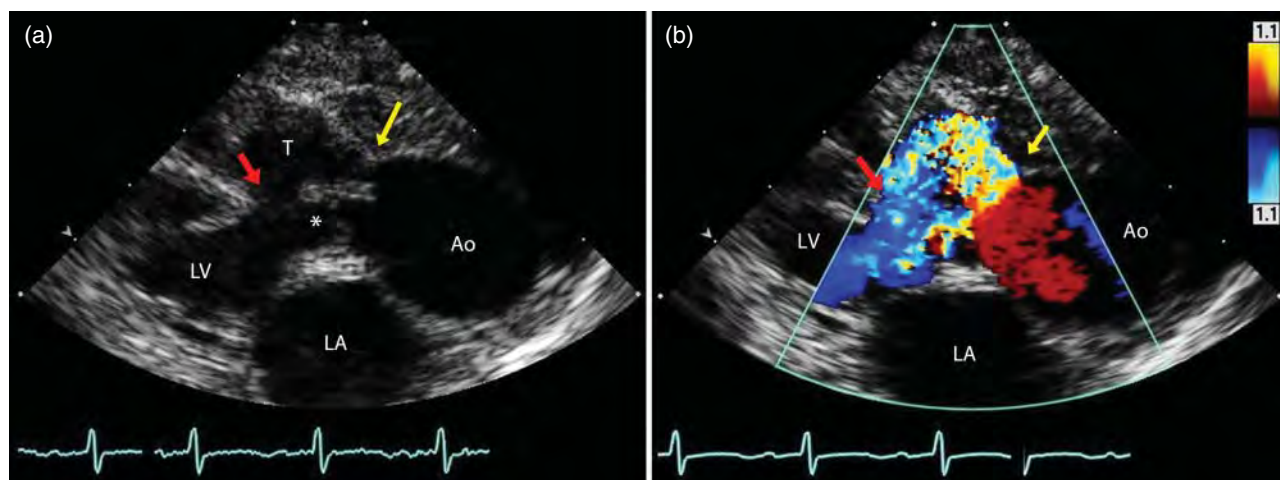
Parasternal long-axis images of a neonate with a type 3 (intraseptal aneurysm) aorto-left ventricular tunnel (AoLVT). (a) A two-dimensional anatomic scan; and (b) the prominent diastolic flow from the aorta, through the tunnel into the ventricular outflow tract using color flow Doppler. The yellow arrow indicates the aortic orifice of the tunnel, which in this case was elliptical and somewhat restrictive. The red arrow indicates the ventricular orifice which in this patient was quite large. The asterisk is positioned in the immediate subaortic portion of the left ventricular outflow tract. Ao, aorta; LA, left atrium; LV, left ventricle; T, aorto-ventricular tunnel.
